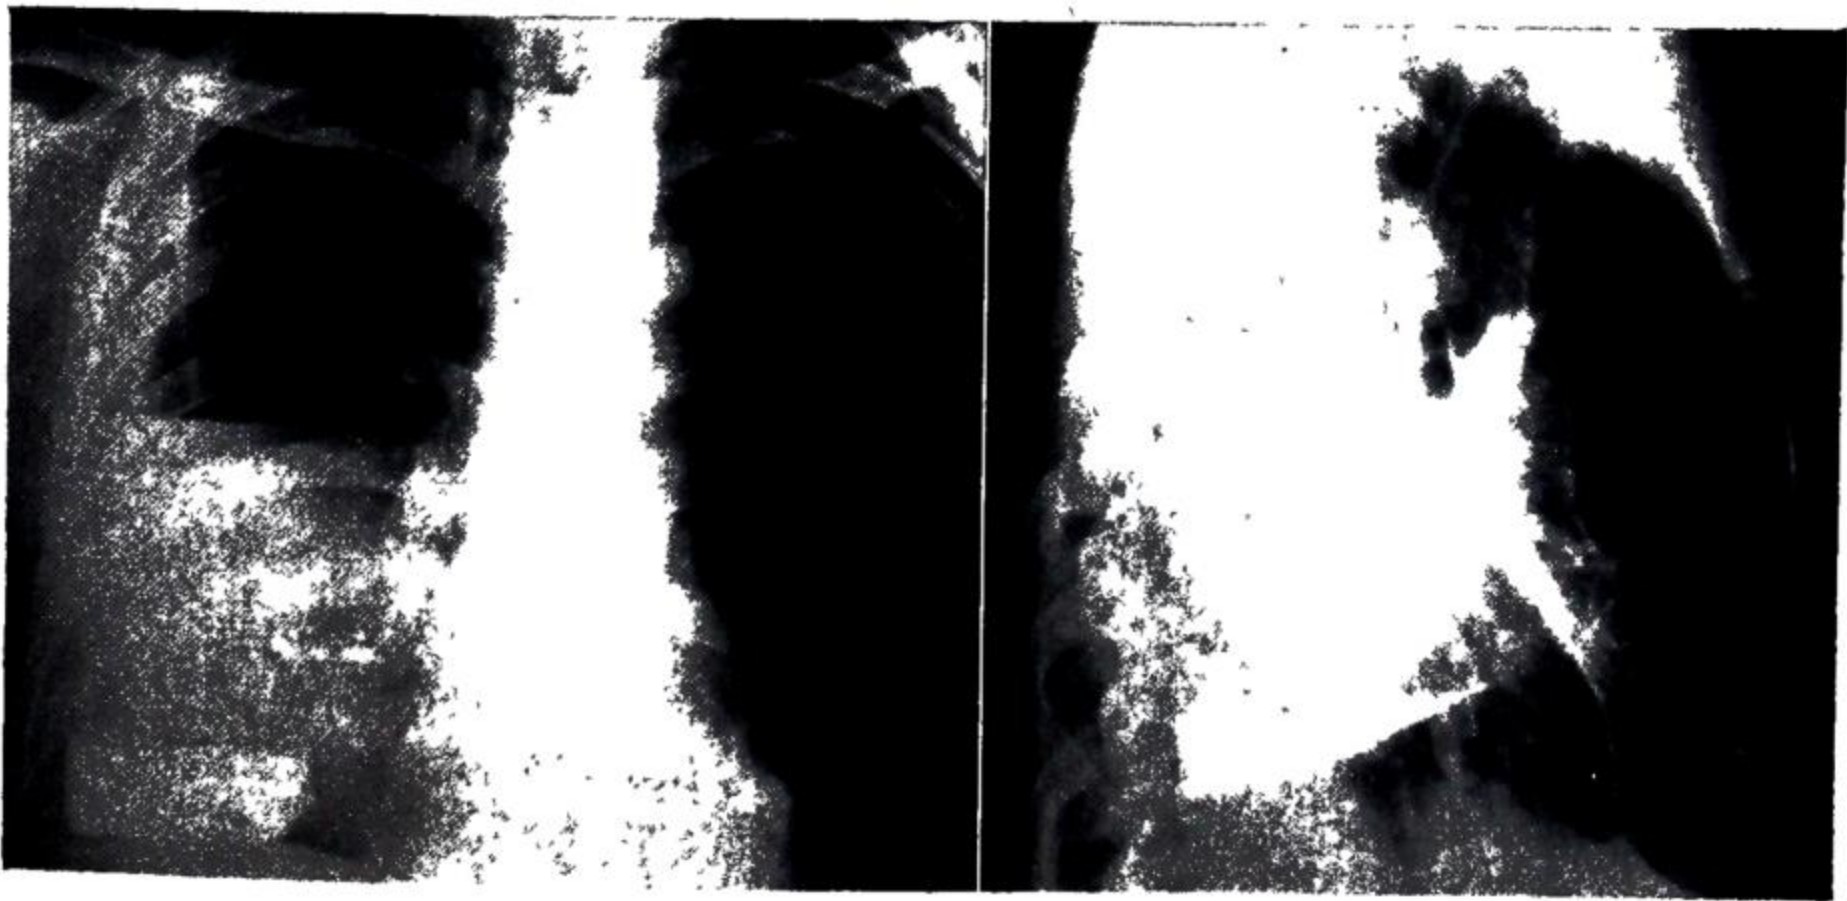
Postero-anterior and lateral radiograph of an empyema after injection of iodised oil to delineate the lower limits of the space prior to drainage.
